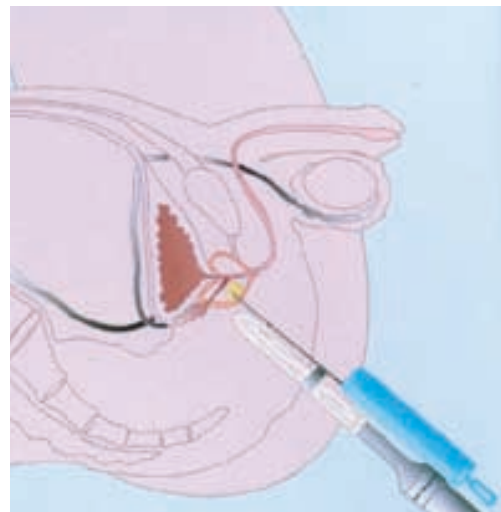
Transrectal ultrasound guided biopsy of the prostate.
